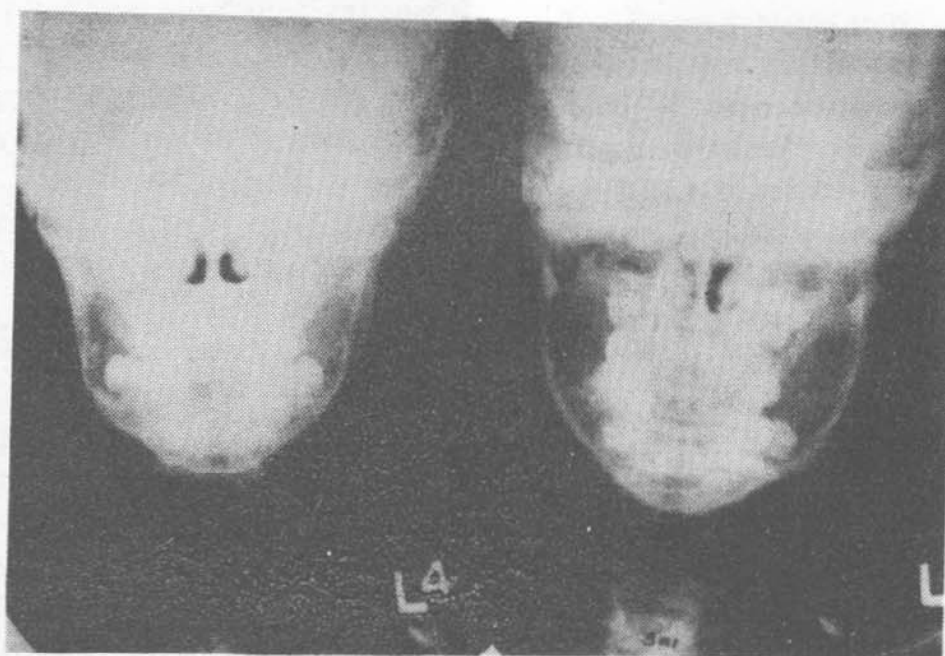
Radiographic findings of cherubism. The posteroanterior view of mandible shows bilateral expansion of the mandible with extensive destruction, bony expansion and extensive disruption of dentition. (L) DRP; (R) PRP.
